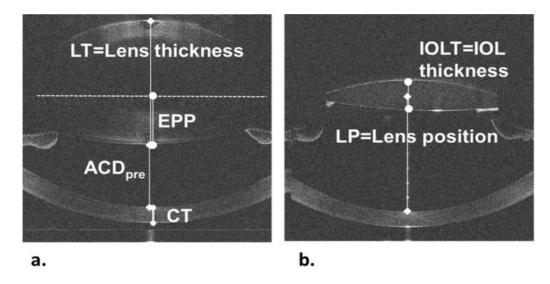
Raw optical coherence tomography images OD, (a) Preoperative measurement. (b) Postoperative measurement. ACD = anterior chamber depth, EPP = equatorial plane position, CT = corneal thickness.
